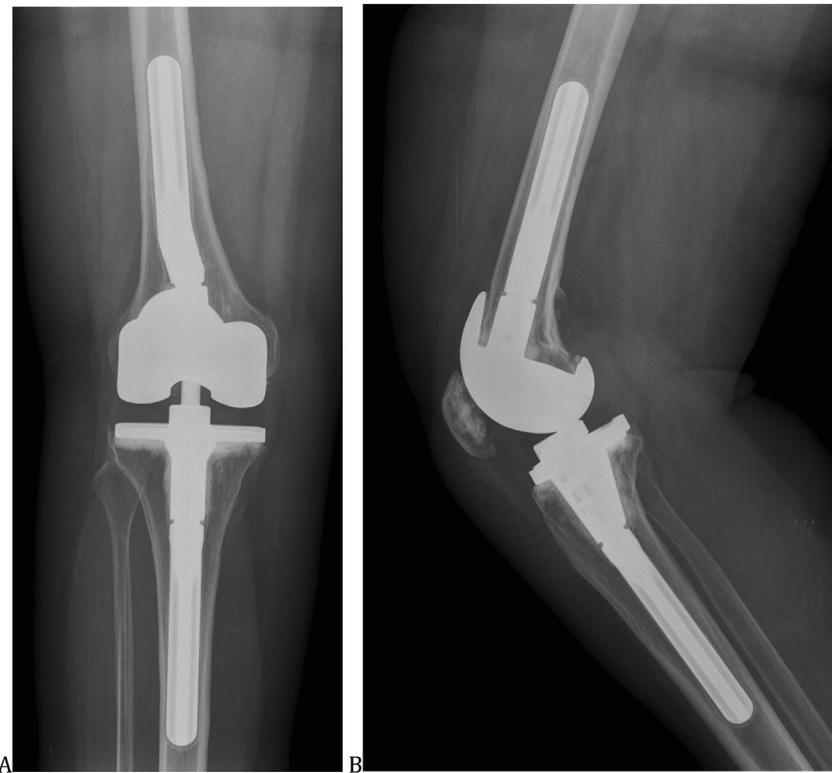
Example of AP (A) and Lateral (B) radiographs showing Grade 2B loosening around both tibial and femoral components.
